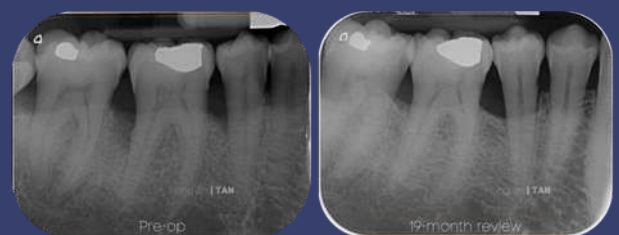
Case 1 - Radiographic bone fill of LR6 and LR5 which remained stable at 19 months.
